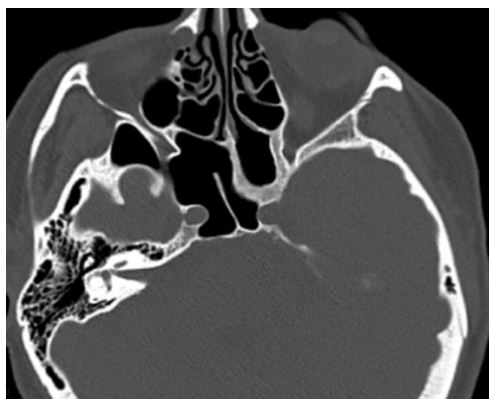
Axial CT slice, bone window, demonstrating a particular case in which the left sphenoid sinus is occupied by a very large ethmoid cell
